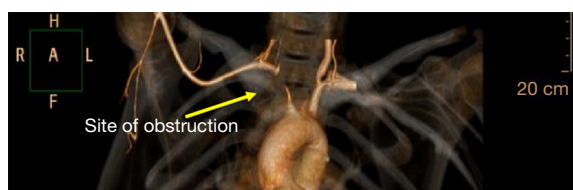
CT right upper limb angiogram shows carotid artery stenosis.
